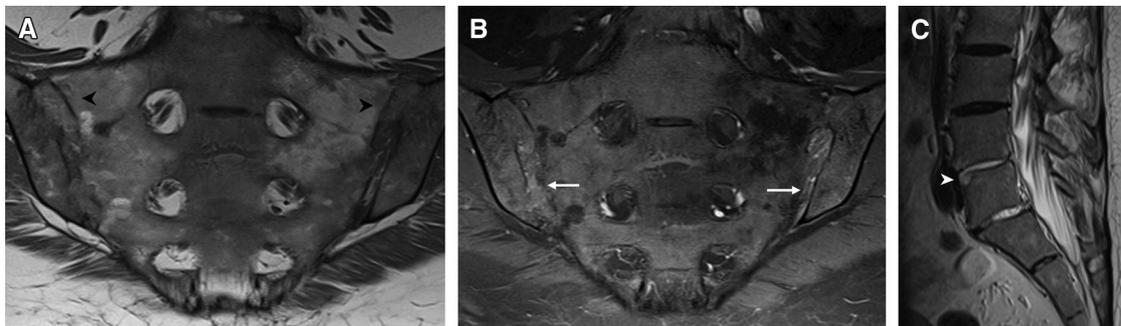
Ankylosing spondylitis with active sacroiliitis. (A) Axial T1-weighted image shows subchondral fatty infiltration around both sacroiliac joints with partial ankylosis consistent with chronic sacroiliitis (black arrowheads). (B) Axial fat saturated T1-weighted postcontrast image shows mild enhancement within both sacroiliac joints indicating active inflammation. (C) Sagittal T2-weighted magnetic resonance imaging lumbar spine demonstrates signal hyperintensity and erosion within the anteroinferior endplate of L4 and anterosuperior endplate of L5 vertebral bodies (white arrowhead) consistent with Romanus lesions (shiny corner sign).
